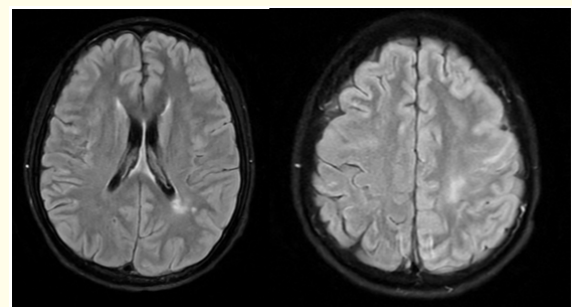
The Cranial MRI post-MPPT now showed interval resolution of the T2-flair hyperintensities along the left frontal and parietal lobe sulci. There are still some residual hyperintense lesions at the left precentral gyrus but the cerebral edema is also resolving.
